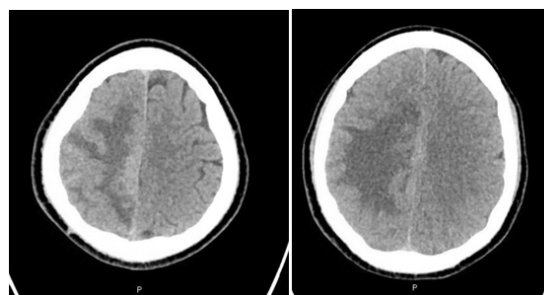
CT head showed Ill-defined hyper-density lesion along the right high parafalcine region.
